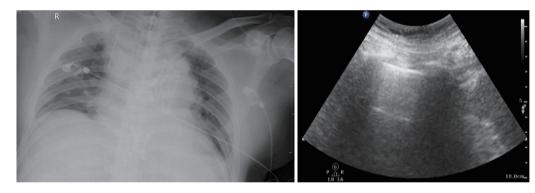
Chest radiographs and lung ultrasound images from a postoperative patient. A 52-year-old male underwent surgery of the ascending aorta and total aortic arch replacement concomitant with a stent elephant trunk procedure for the descending aorta. Upon arrival to the CSICU, the patient suffered from severe hypoxemia ( $PaO_2/FiO_2$  ratio =78.6 mmHg). Left panel: chest radiograph. There are no specific findings in both lungs. Right panel: lung ultrasound. The image shows the absence of pulmonary edema, lung consolidation, or pleural effusion.
